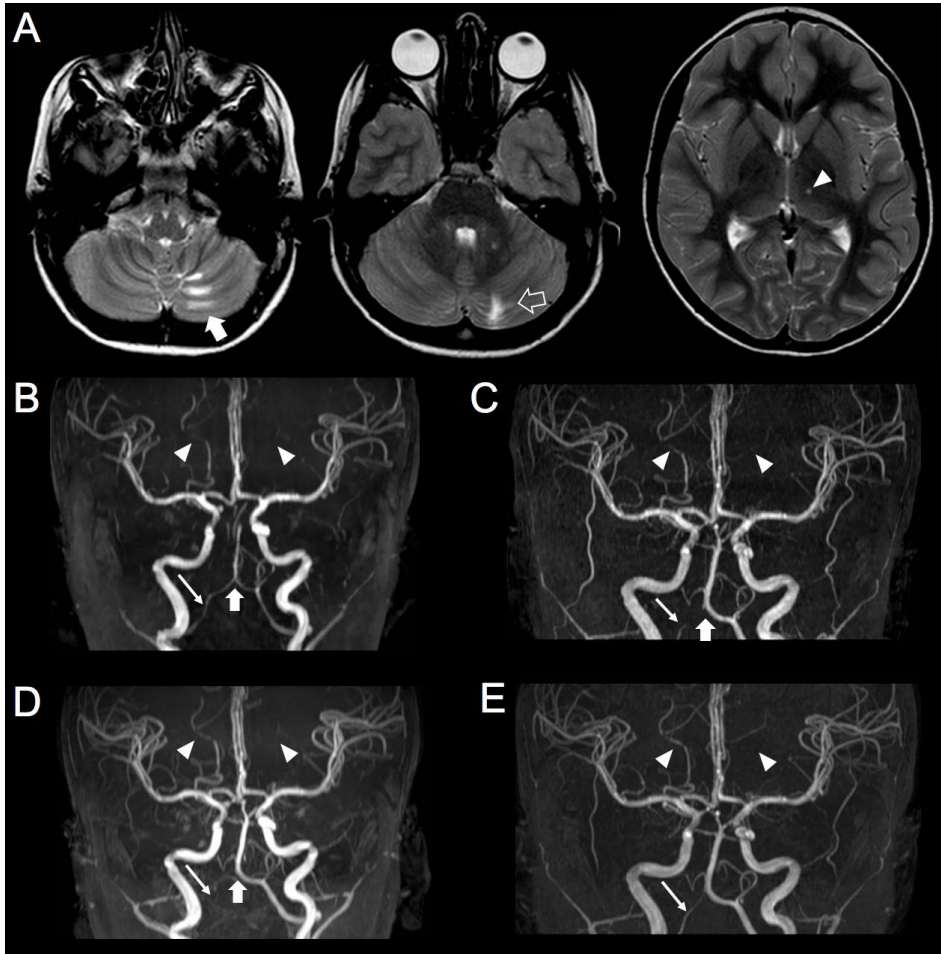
Neuroimaging of patient #38. Brain MRI and MRA with multiple unilateral asynchronous AIS in the left PICA and PCA perforators associated with multiple stenosis of the V3 and P1/P3 segments due to multiple dissections
